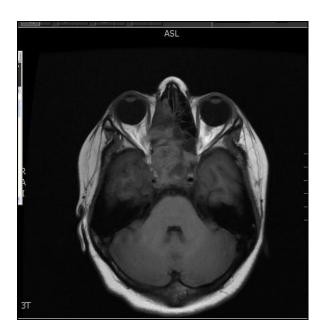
MRI showing diffuse mucosal thickening and enhancement with fluid noted within the sphenoid sinus extending anteriorly into the ethmoid and the right frontal sinus. The sphenoid sinus is expanded with erosion of the sphenoid bone. Possible erosions occur into the base of anterior cranial fossa with associated diffuse thickening of meninges in the right cerebral hemisphere suggestive of intracranial extension.
